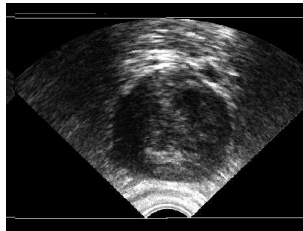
Transrectal ultrasound image
